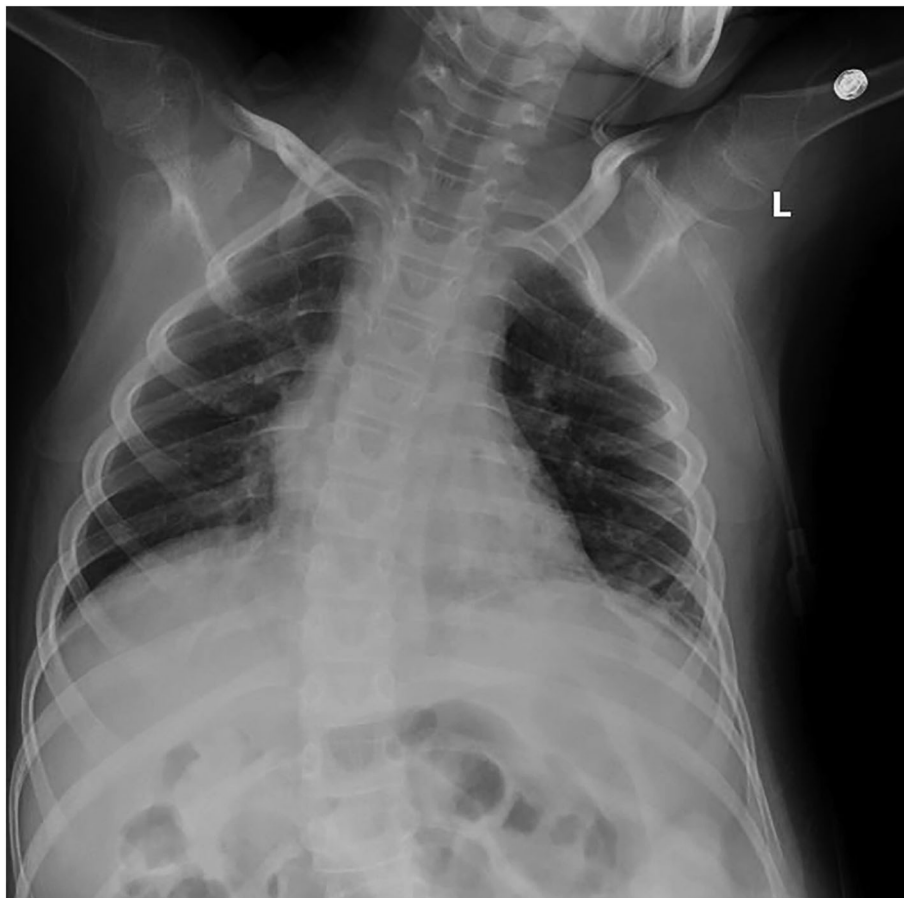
Chest x-ray showing no evidence of foreign body
